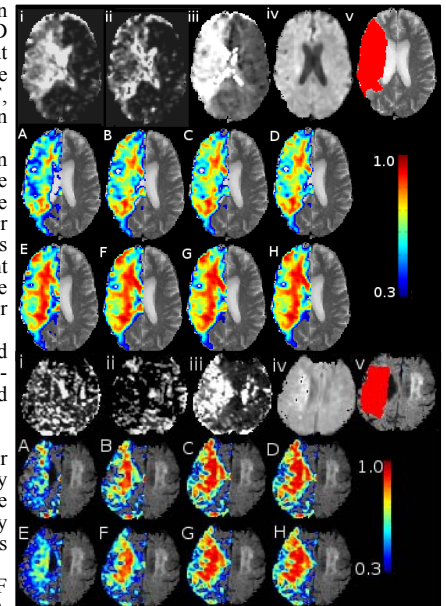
(top) & 1b(bottom): Single slice P -maps from 2 patients. Acute images MTT_G (i), MTT_L (ii), FM_{adj} (iii), DWI (iv), and F/U lesion (v). P -maps thresholded at 30% for models A-H.
